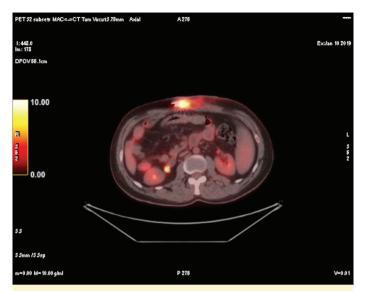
Focal, severe FDG uptake in favor of driveline infection.
